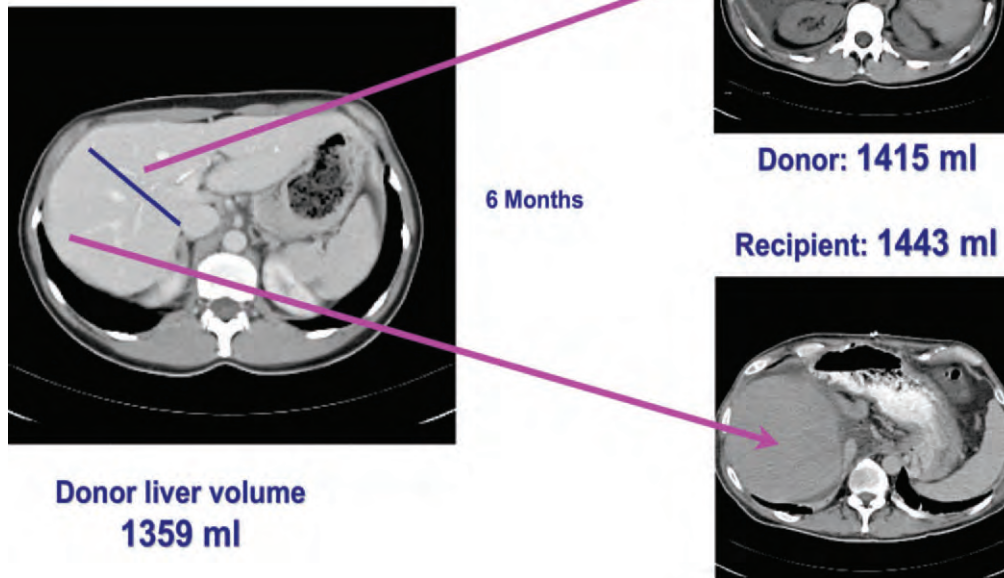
CT imaging of a live liver donor prior to resection (*left*) and the subsequent regrowth of remnant and allograft hemilivers in donor and recipient, respectively.
